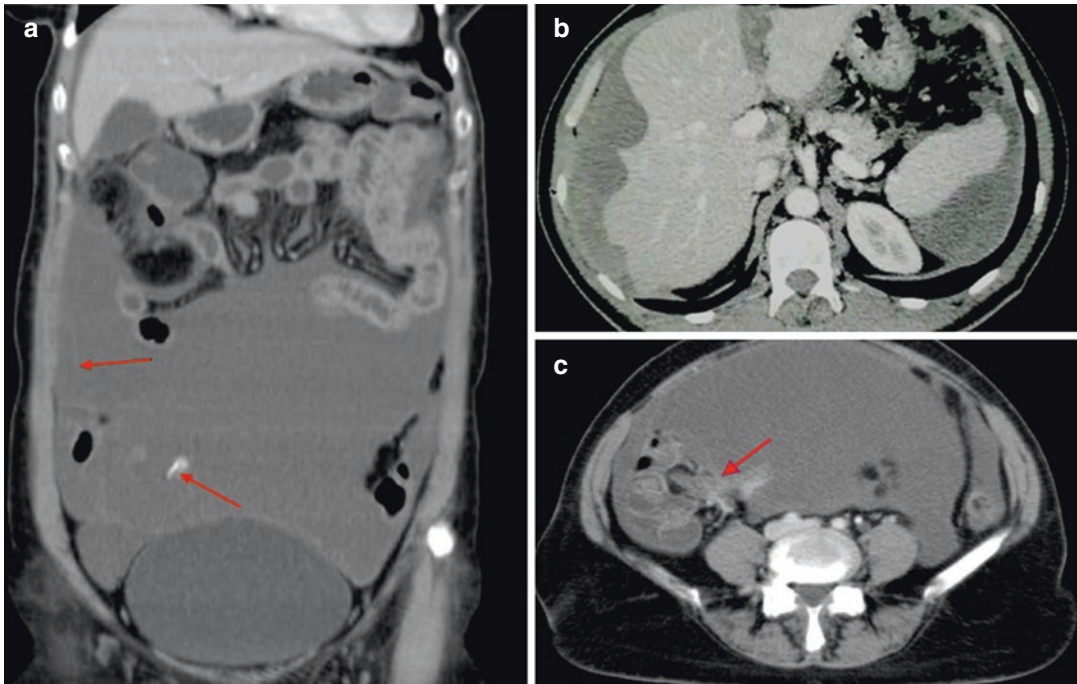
Characteristic CT findings in PMP. (a) Loculated fluid collections with areas of calcification, sparing of the small bowel; (b) scalloping of the surfaces
